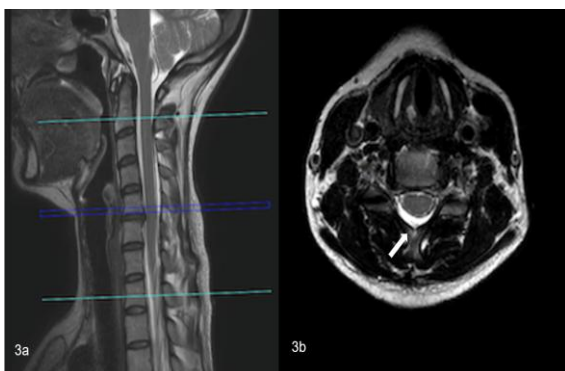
A spinal extradural collection in the sagittal MRI (T2-sequence) expanded between C3 and C5, confirming the CSF leakage (arrows).
